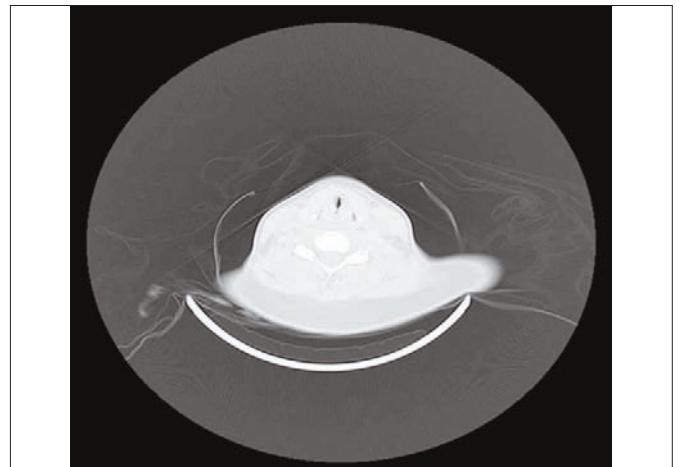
CT Scan image taken at the level of 4th cervical vertebrae showing slit like airway.
